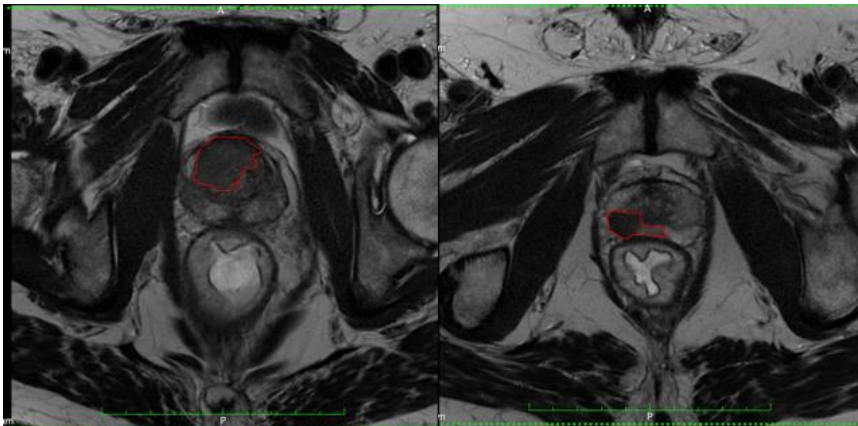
Index lesions delineated on T2-weighted sequences in the transition and peripheral zones.
